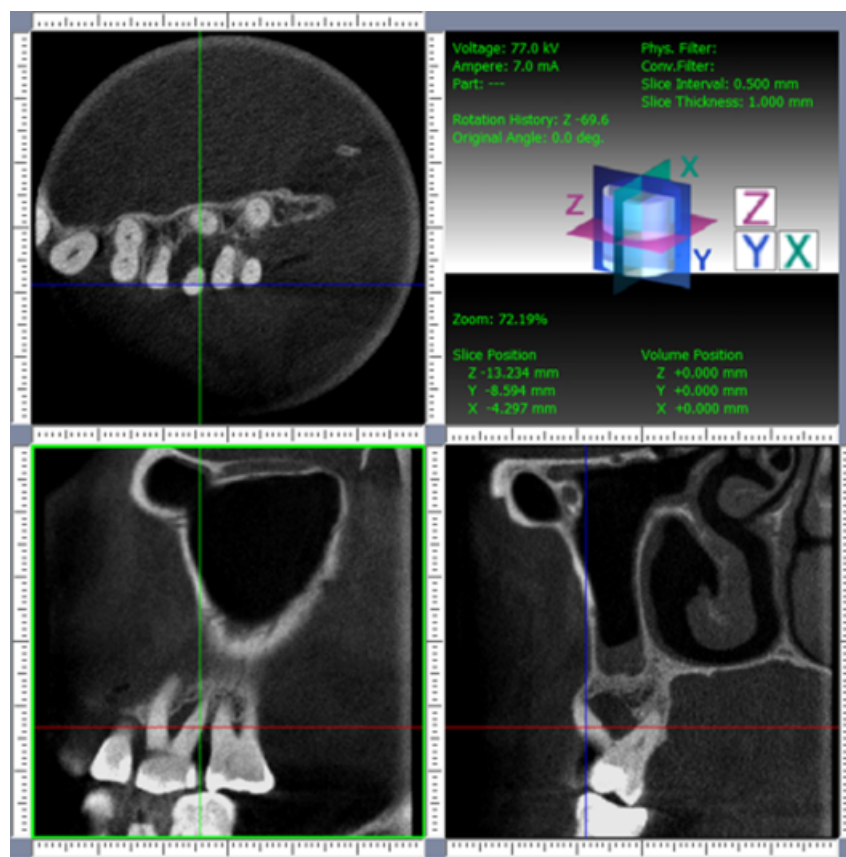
Cone beam computed tomography with horizontal, sagittal and transversal sections of the first and the second left maxillary molars (subject no. 4).
